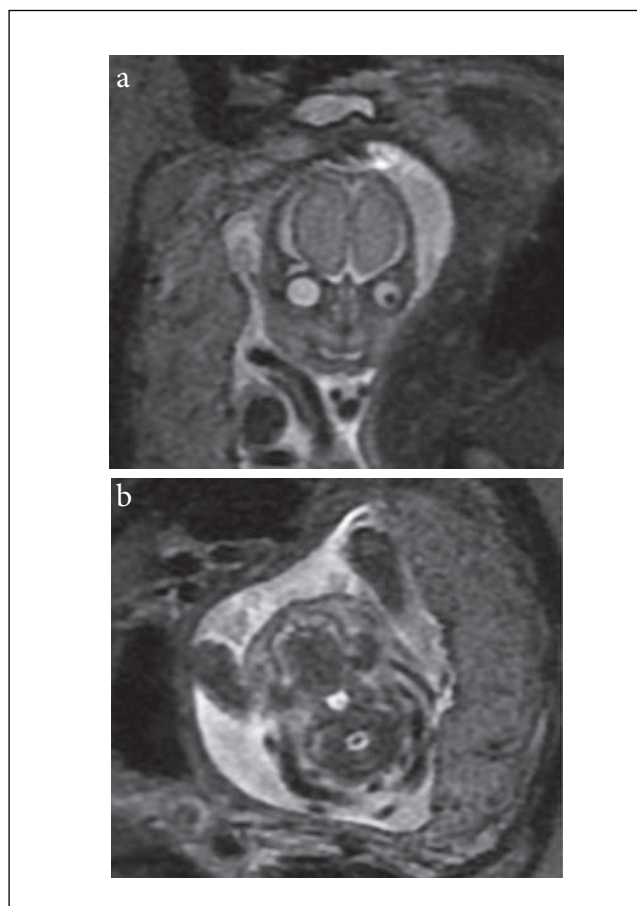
Fetus, 23 weeks of gestational age (GA). MRI, SSFSE sequence, T2-weighted image (T2WI). Normal MR appearance of the lip, alveolus and palate in coronal (a) and axial (b) plane.
